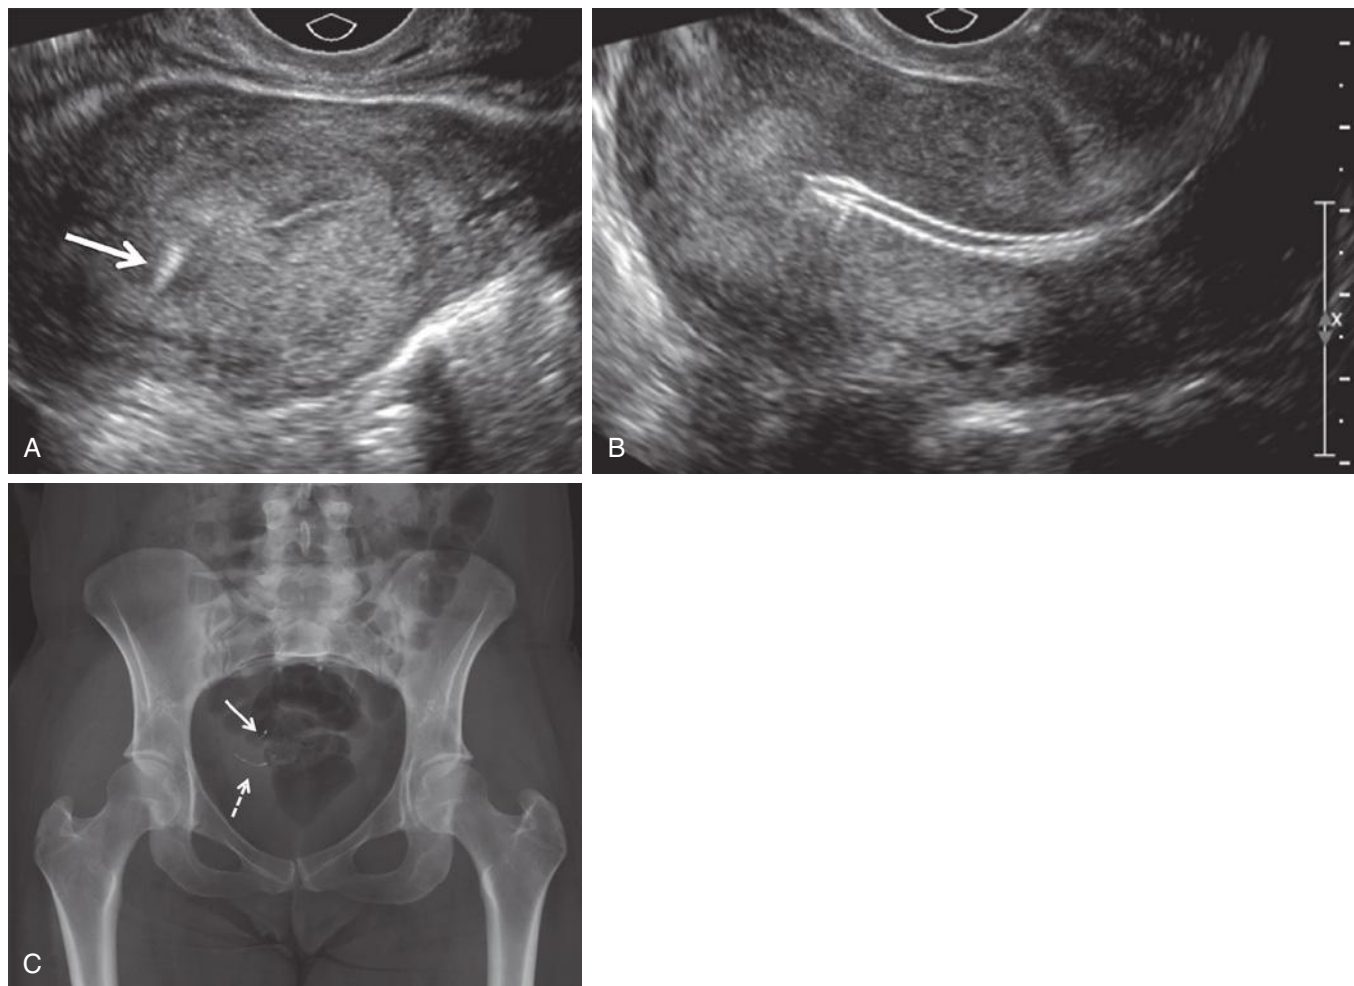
Essure device in abnormal location. A, Transverse transvaginal sonographic image of the uterine fundus demonstrating the right Essure device (*arrow*) in the appropriate location in the interstitial portion of the right fallopian tube. The left device is not visualized on this image. B, Midline sagittal transvaginal sonographic image of the uterus demonstrating the left Essure device centrally located within the endometrial cavity. C, Radiograph confirms abnormal location of the left Essure device (*dotted arrow*). *Solid arrow*, right Essure device. (Courtesy Department of Obstetrics and Gynecology, Yale University School of Medicine, New Haven, CT.)
